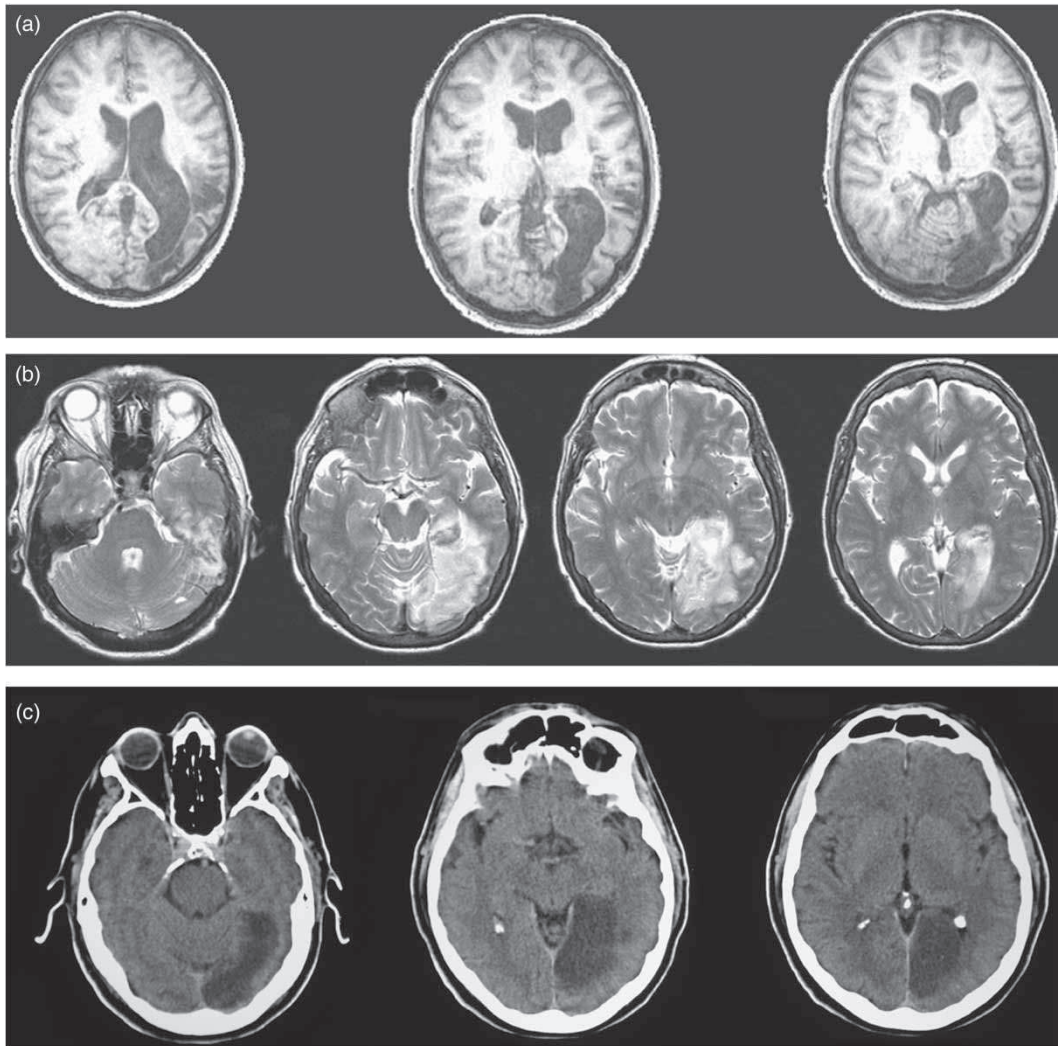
Magnetic resonance imaging (MRI) scans of the lesions of patients (a) E.L., (b) G.B., and (c) S.H. Images are presented following radiological convention (left hemisphere depicted on the right).
